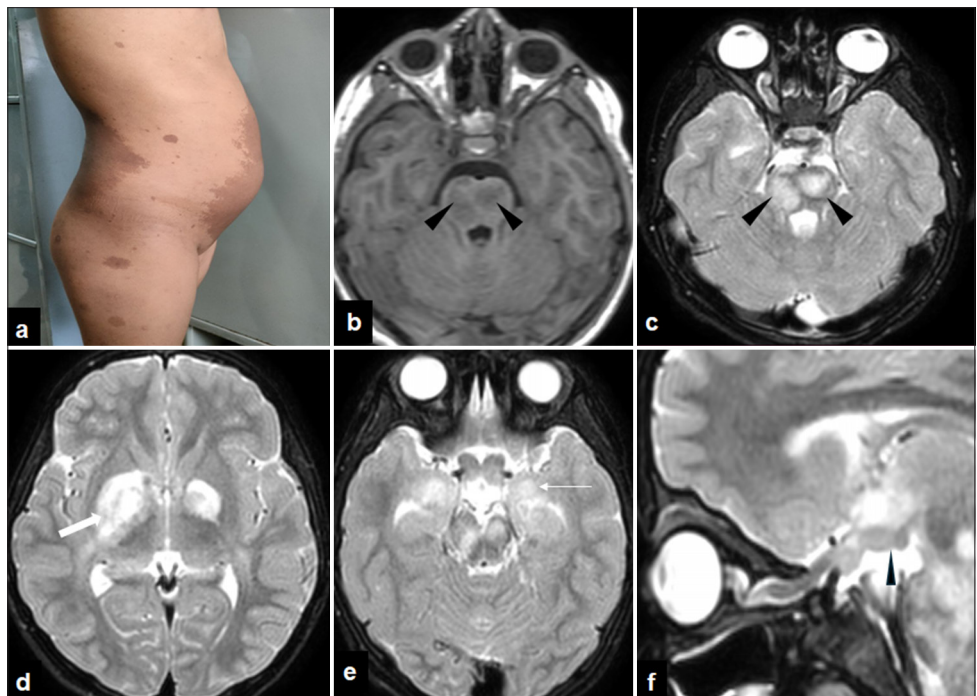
(a) Clinical photograph of child showing multiple café-au lait macules, well circumscribed, dark brown pigmented skin lesions with sizes ranging from sub centimetric to largest one encircling back, left side of trunk and abdomen measuring about 20 cm. (b) Magnetic resonance imaging of axial T1-weighted images of the brain showing multiple hypointense areas in the midbrain (black arrow heads). (c) Axial T2-weighted (T2W) images of brain show multiple focal hyperintense lesions at brain stem (black arrow heads), (d) bilateral lentiform nucleus (thick white arrow) and (e) medial temporal lobes (thin white arrow). (f) Sagittal T2W images of brain and orbit shows thickened optic nerves, chiasma, and proximal optic tracts (black arrowhead) arrowhead iso- to hypointense to brain parenchyma.
